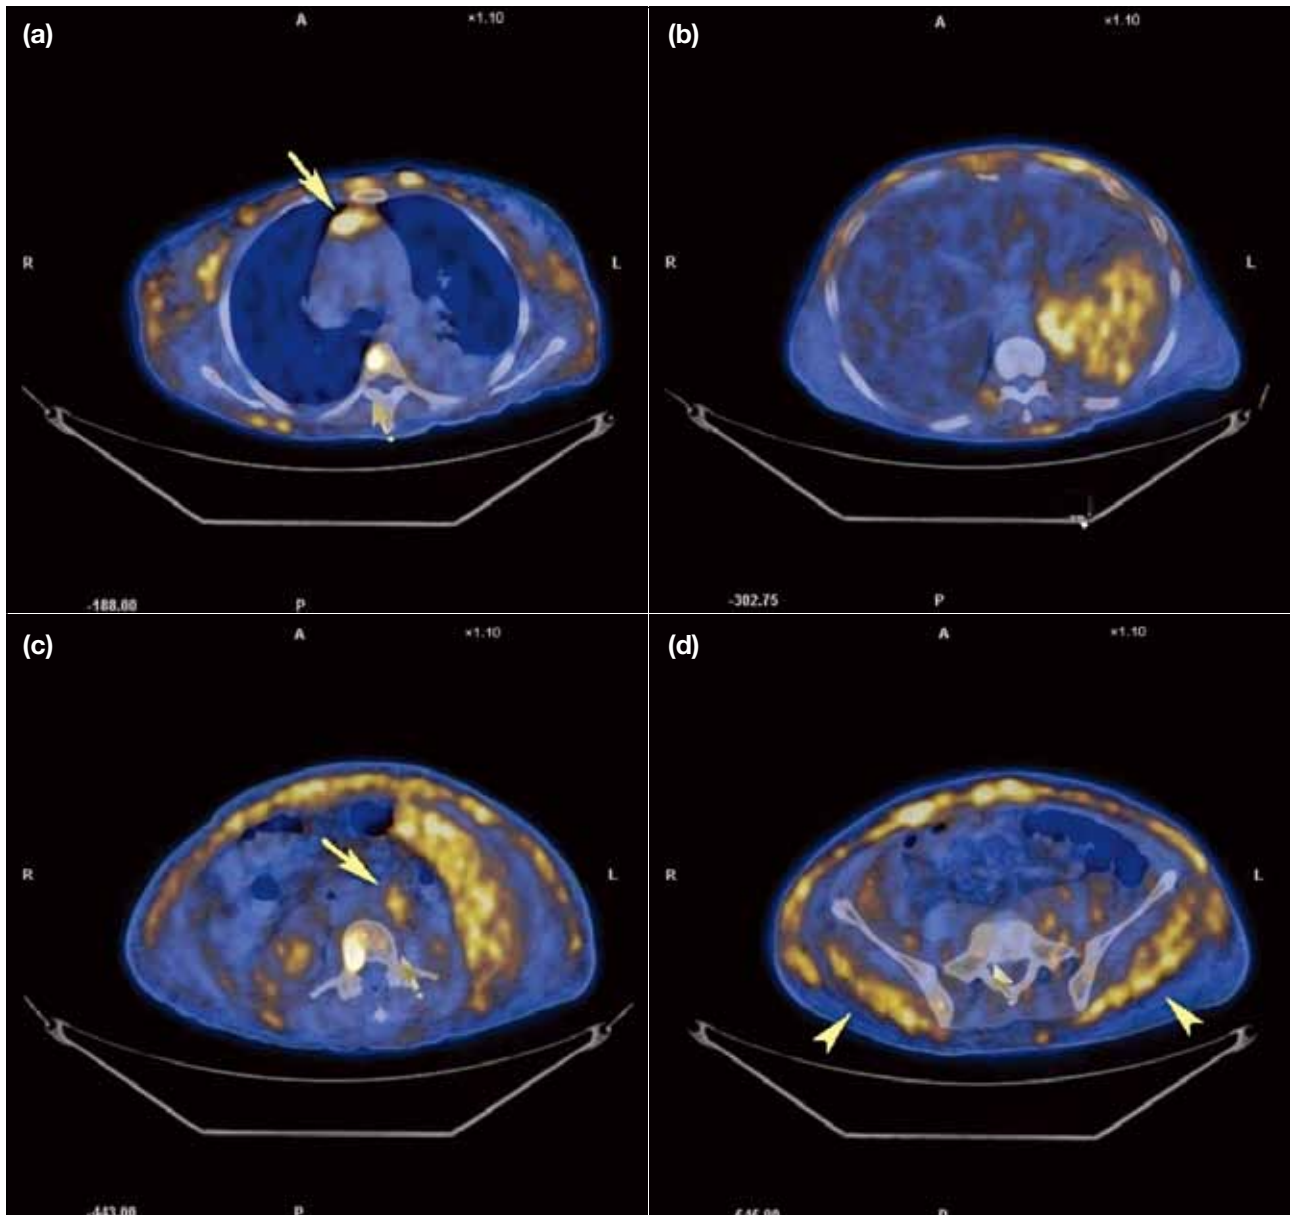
Axial positron emission tomography/computed tomography (PET/CT) fusion images showing small hypermetabolic lymph nodes (large arrows) in the (a) anterior mediastinum and (c) paraaortic regions in abdomen. (b) The spleen shows abnormally high ^{18}F -deoxyglucose uptake compared to the liver. (d) Involvement of fat bilaterally in the gluteal regions (arrowheads).
